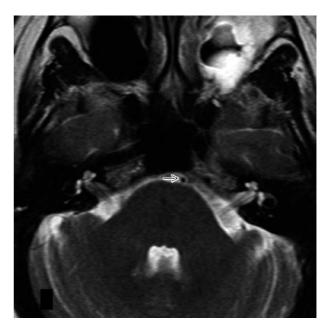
Axial T2-weighted image of the brain showing a hypoplastic basilar artery inferior to the carotid-basilar anastamosis.
